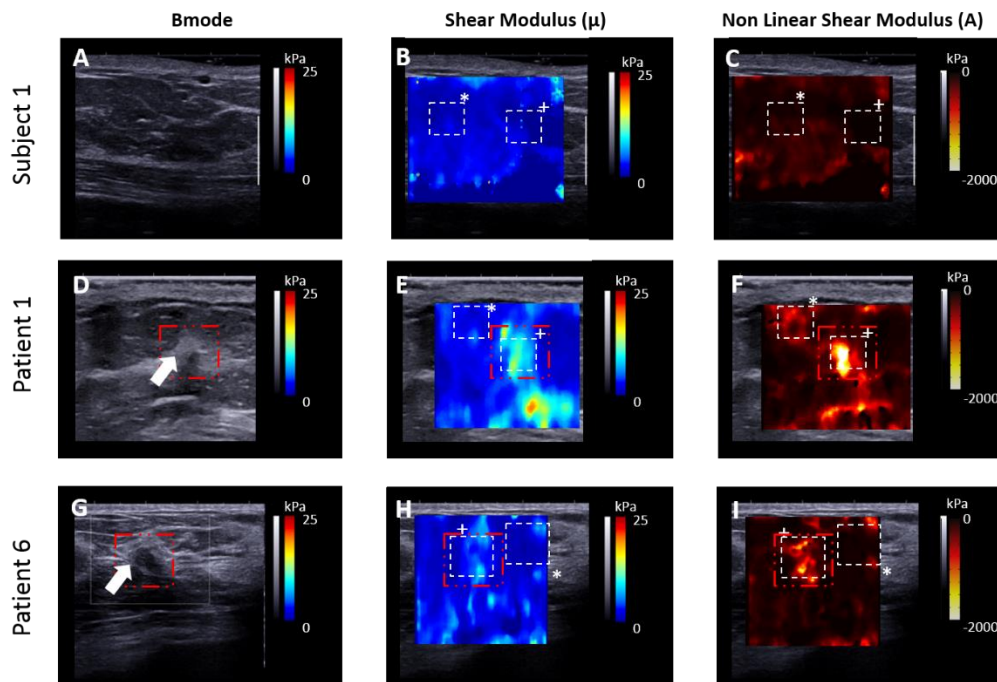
Results of the NLSM on 3 patients, a healthy volunteer, a patients presenting with a tumor and a patient with a benign lesion. The left column shows the ultrasound images where the mass are enclosed in red squares. The center and the right columns show the corresponding images for the shear and the nonlinear shear modulus, respectively. The dotted squares are the ROI's used in the mean and standard deviation values (Bernal et al., 2016).
